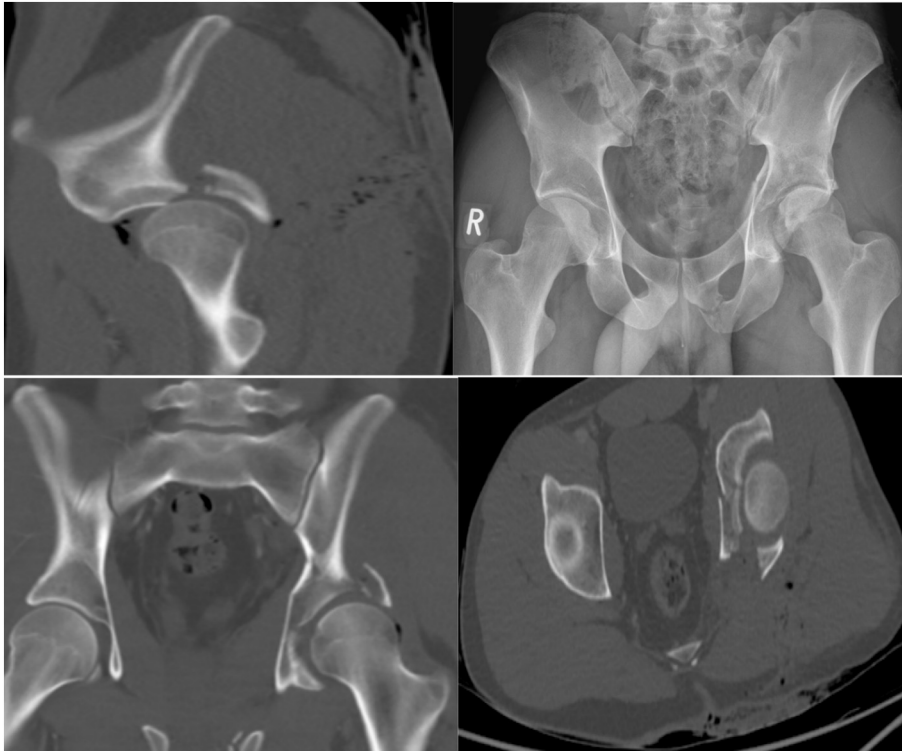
A: AP x-ray binder off in ED, B: coronal CT, C: sagittal CT, D: axial CT.
